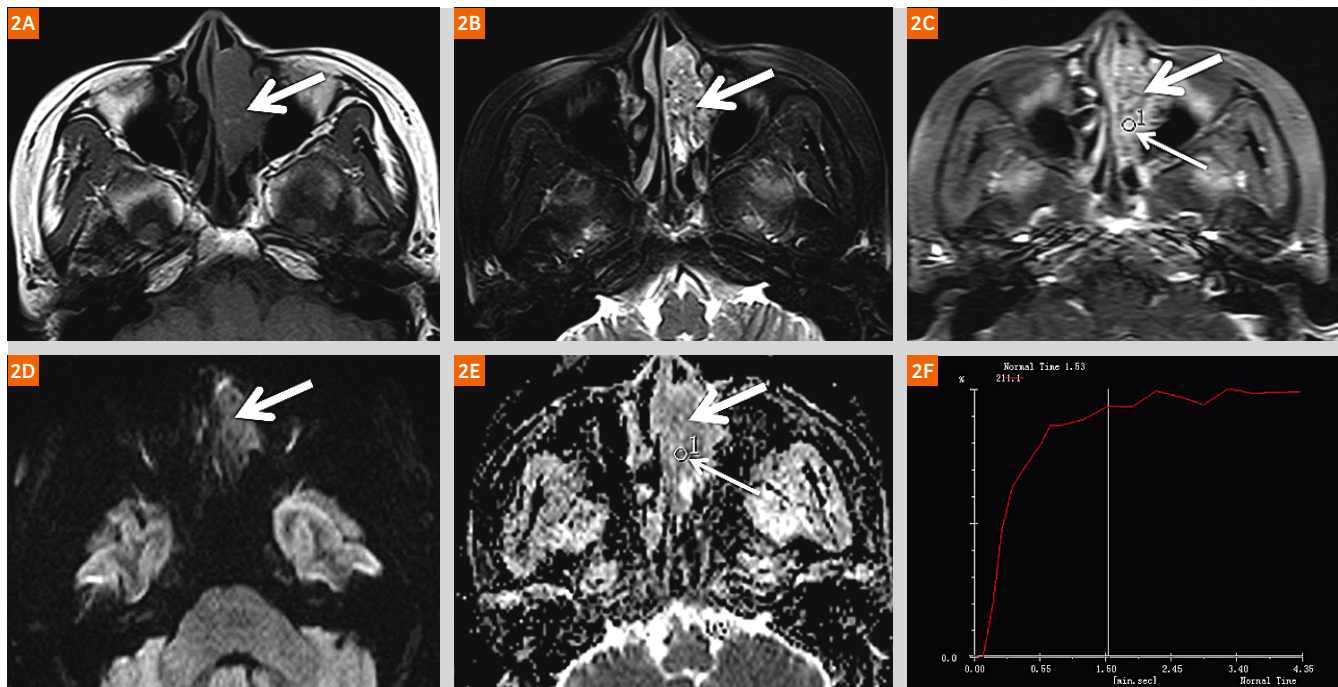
A 43-year-old man diagnosed with rhabdomyosarcoma. The lesion is indicated by the thick arrow and ROI by the thin arrow. 2A: Axial T1-weighted with isointense mass in right nasal cavity and maxillary sinus; 2B: Axial fat-suppressed T2-weighted; 2C: Axial, contrast-enhanced T1-weighted showing marked heterogeneous enhancement; 2D: b-value 1000 s/mm² RESOLVE with high signal intensity in the lesion; 2E: ADC map with low signal intensity in the lesion and mean absolute ADC of 0.482×10^{-3} mm²/s within the ROI; 2F: DCE-MRI time-signal intensity curve in this patient is categorized as type 3 with washout enhancement [8].
